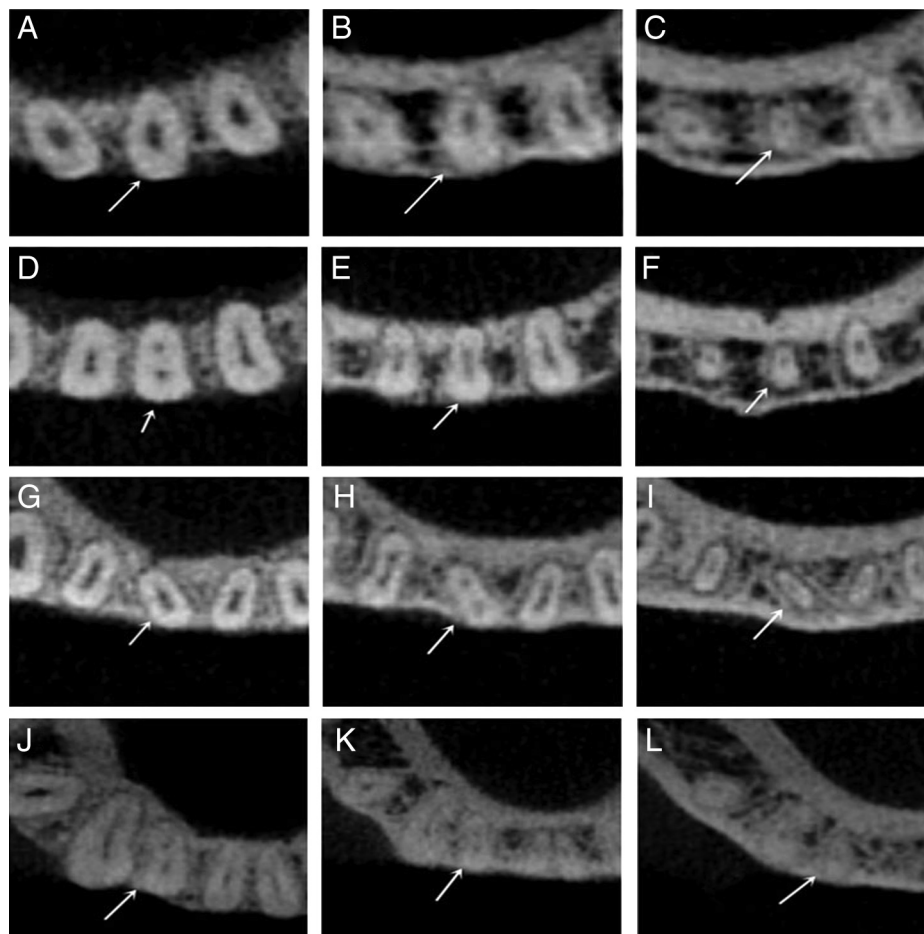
The axial planes of CBCT scanning in the coronal, middle, and apical thirds of the root displayed variations in canal morphology. (Arrows denote the canal morphology.) (A–C) Type I, (D–F) type II, (G–I) type III, and (J–L) type IV.
